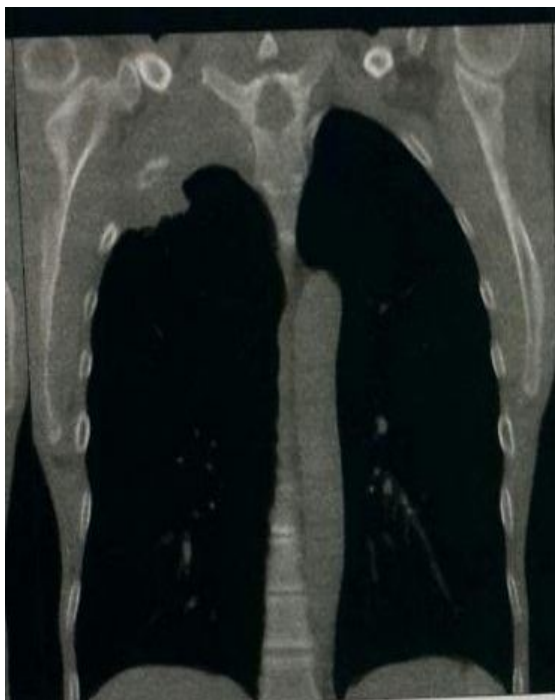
Coronal reformatted CT image shows the right apical tumor invading the chest wall and first and second ribs
